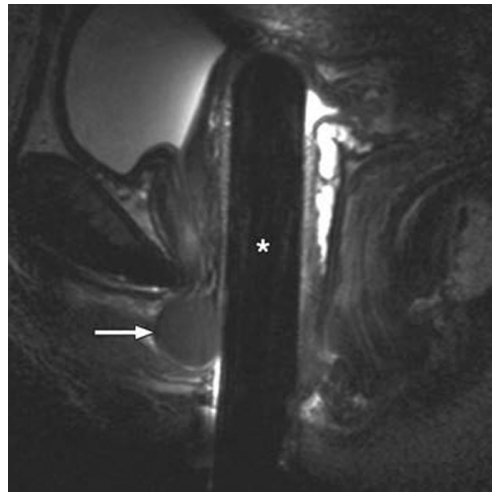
32-year-old woman with increasingly painful lump behind urethral orifice with obstructed urinary flow and dyspareunia. Sagittal T2-weighted 1.5-T image with intravaginal coil (asterisk) shows surgically confirmed infected cyst of Skene (arrow). Lesion has typical location in floor of distal urethra (left-sided) with low-signal-intensity content, which is suggestive of infected cyst of Skene.
